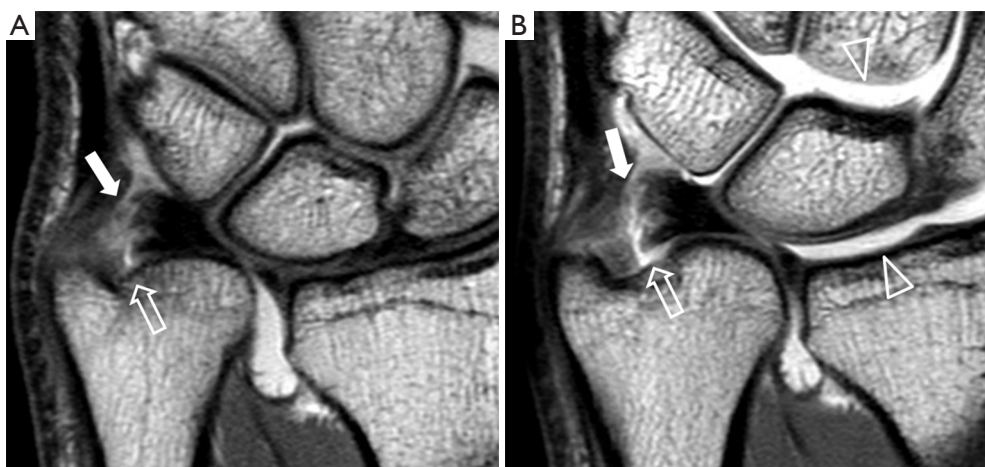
Comparison of TFCC visualization using non-traction MRI (A) and traction MRI (B). Before traction, there is a tear depicted at the foveal attachment (block arrow) of the TFCC but the styloid attachment appears intact (solid arrow). After traction, discontinuity at the styloid attachment can be fully appreciated (solid arrow). The radiocarpal and the mid-carpal joints are widened following traction (arrowheads). TFCC, triangular fibrocartilage complex.
